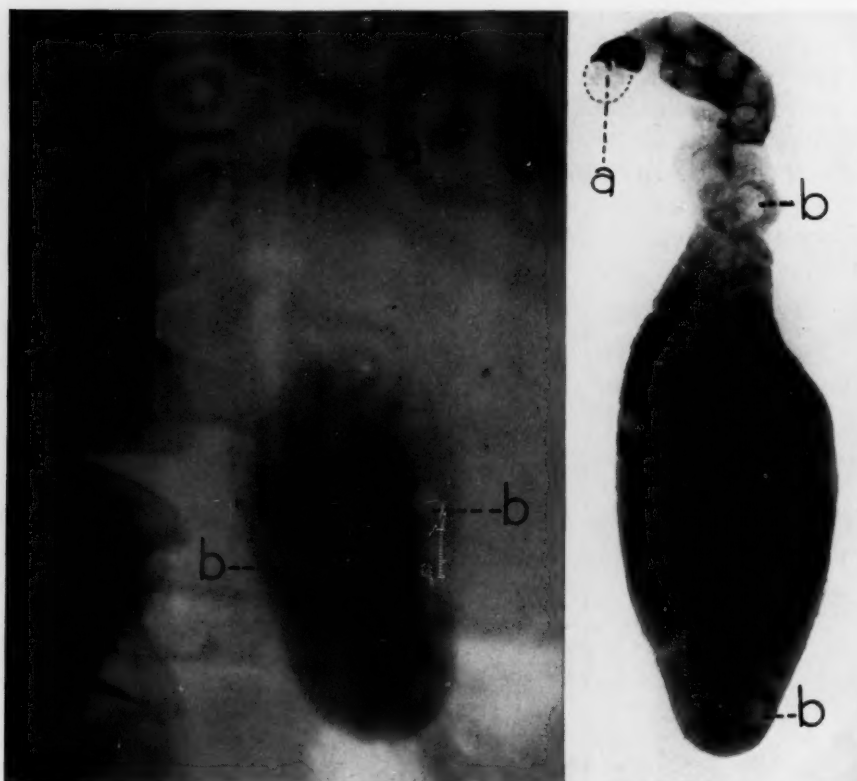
Case 2: Roentgenogram before dye administration. Radiopaque calcium carbonate on gallbladder side of stone in cystic duct (a), radiolucent shadow of cholesterol pigment stones (b) within calcium carbonate paste filling gallbladder.
